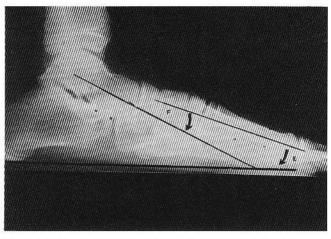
Pronated foot x-ray. The first metatarsal declination angle reduces somewhat (E). The lateral first metatarsal angle increases in the positive direction as the talus significantly plantarflexes (F).
